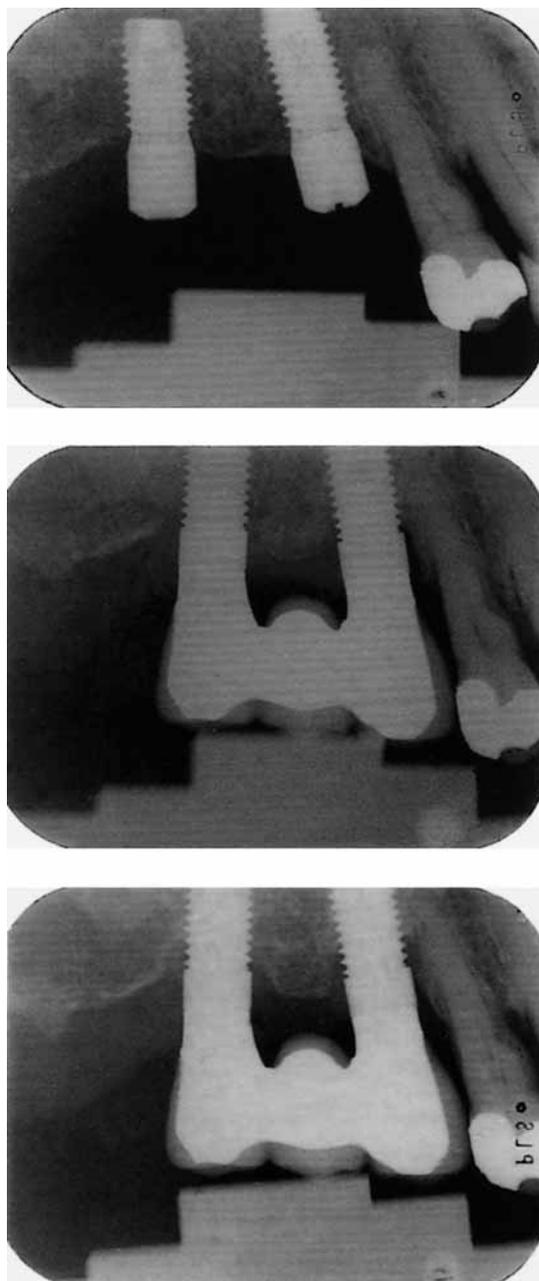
X-rays of two implants in patient #8 after connection of the healing abutments (A), after connection of the bridge (B) and 8 months after loading (C). Bone loss is evident around both implants at 8 months.
